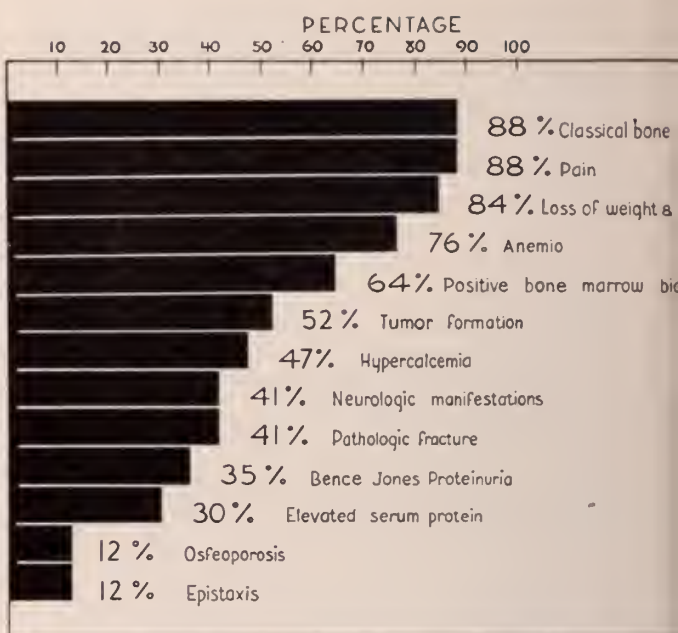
Percentage of occurrence of clinical, radiographic, laboratory abnormalities in 17 cases of multiple myeloma.
